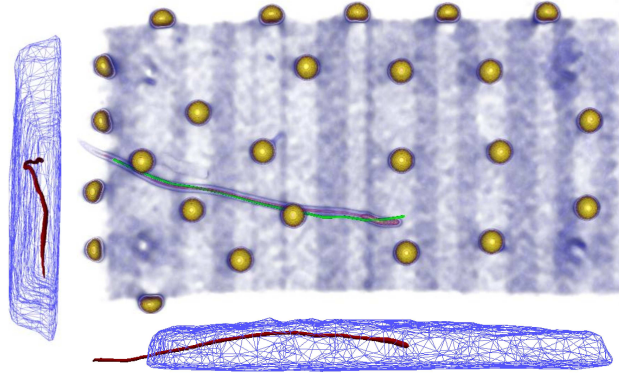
CT scan after the robotic insertion. The desired trajectory is shown in green and the path taken by the needle is shown in red.
